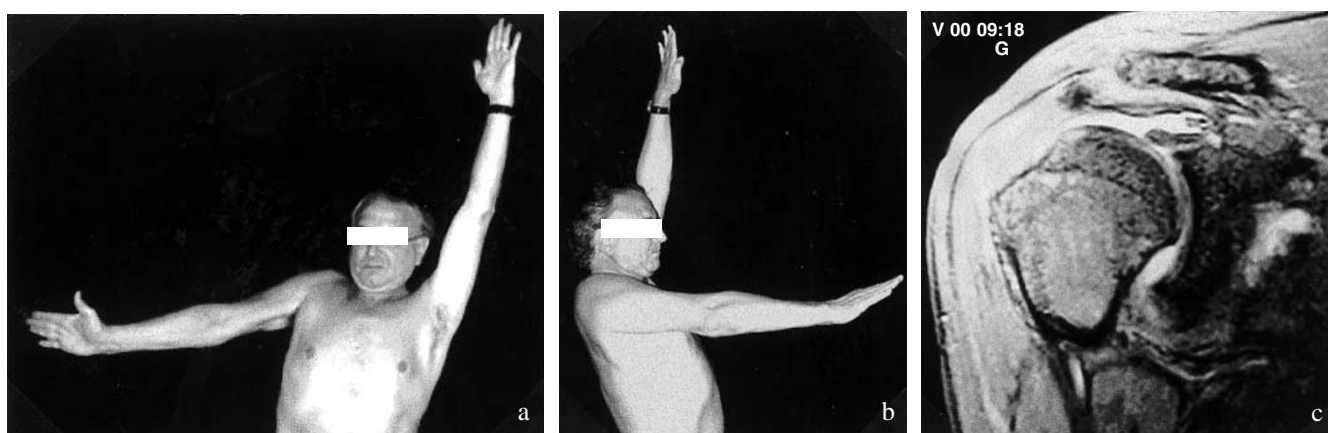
Case 2. a, b A 59-year-old man with a massive rotator cuff tear of the right shoulder, involving the supraspinatus and infraspinatus tendons, and an impairment of shoulder abduction (80°) and flexion (80°). c MRI scan shows the massive rotator cuff and the upward migration of the humeral head
